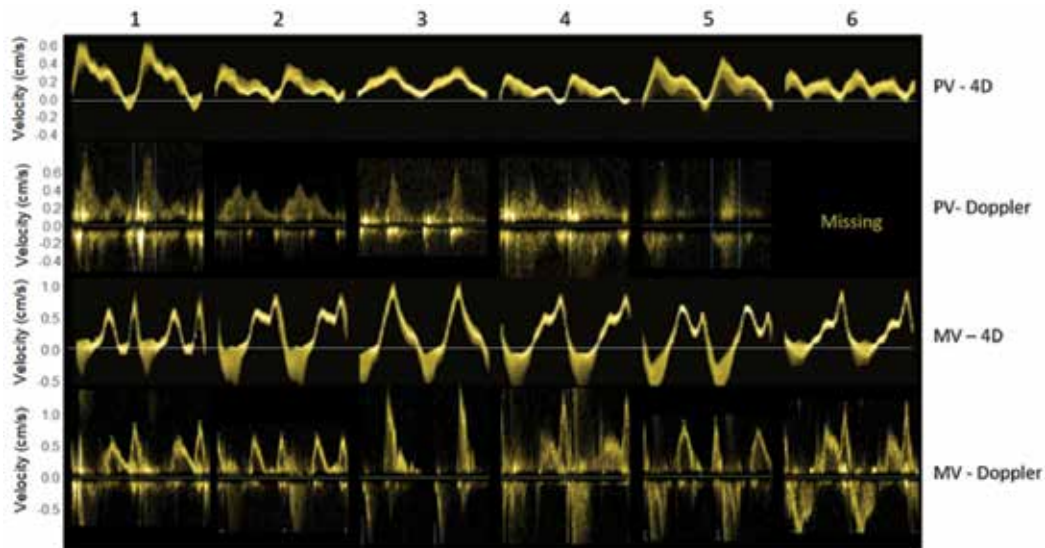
The synthetic 4D flow derived PW Doppler velocity curves alongside the authentic PW Doppler. The sample volume for the PV acquisitions was located in the right superior PV, while the mitral valve profiles were extracted from the leaflet tips.
